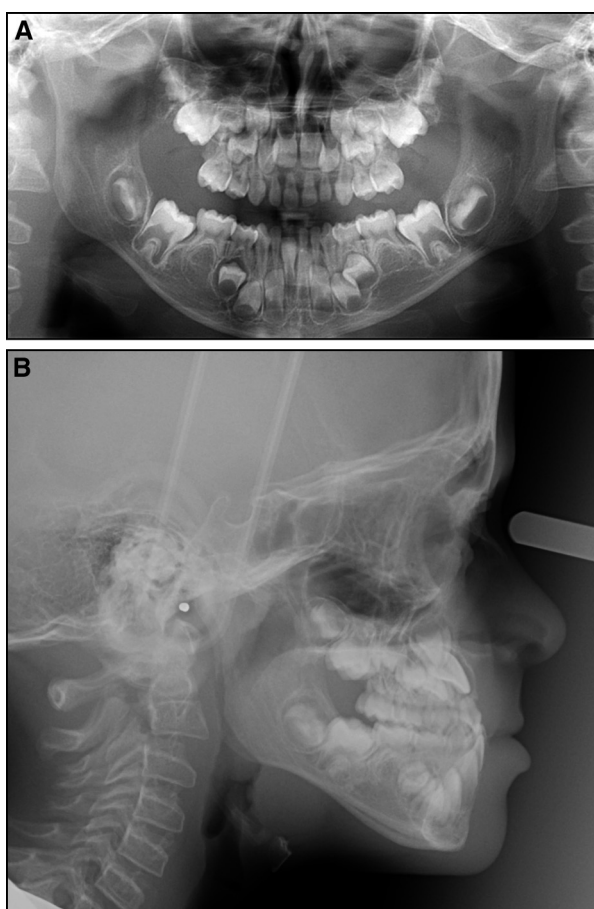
Pretreatment radiographic records in patient 1: A, panoramic radiograph; B, lateral cephalogram.
